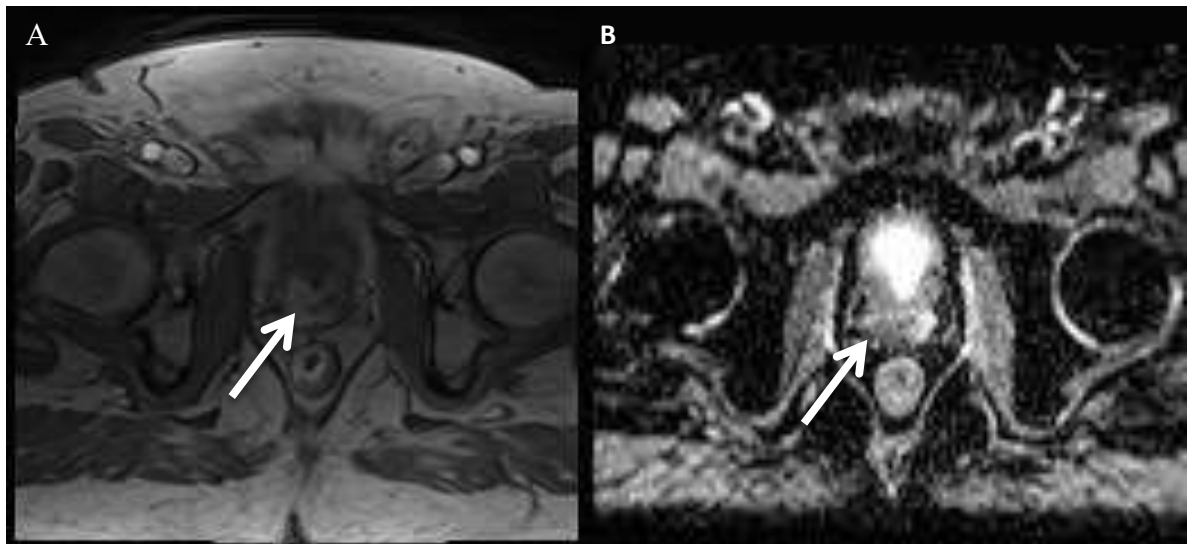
Local recurrence to left of the prostatic bed demonstrated on MRAC PSMA PET series images in patient BCR018(white arrow)
